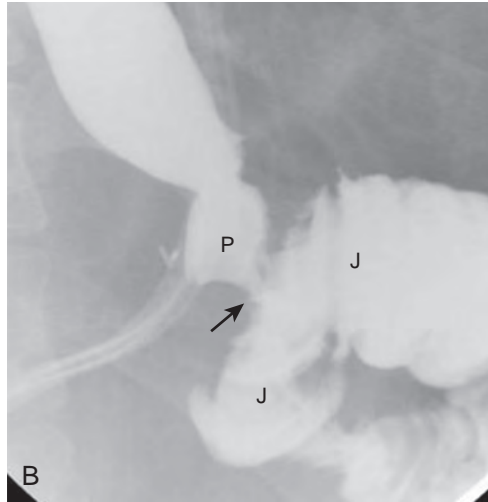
Roux-en-Y Gastric Bypass A. RYGB anatomy. A small gastric pouch (P) is created to exclude the remainder of the stomach and the duodenum from the path of food. There is a gastrojejunostomy with a jejunal Roux limb (J) anastomosed to the pouch via a narrow stoma and a more downstream jejunojejunostomy (arrow). This creates an alimentary limb (pouch, Roux limb), biliopancreatic limb (including the excluded stomach and duodenum), and downstream common channel. B. UGI image in the LPO position shows a small gastric pouch (P) with a narrow anastomosis (arrow) to the jejunal Roux limb (J). Note the surgical drain. C. Axial contrast-enhanced CT scan with oral and IV contrast shows an opacified small gastric pouch (P) anastomosed (arrow) to the jejunal Roux limb (J). There is a small amount of fluid in the excluded stomach (ES).
